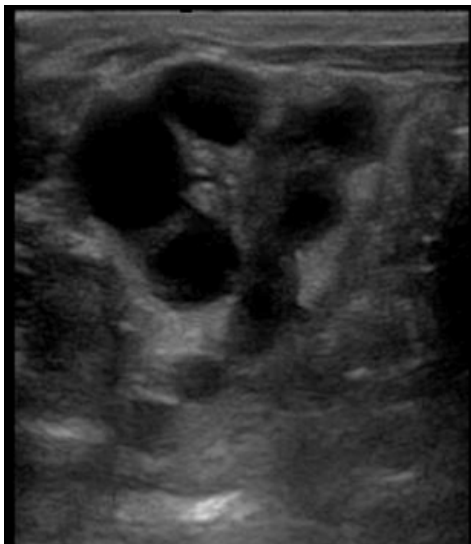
Ultrasound of a multicystic dysplastic kidney.
